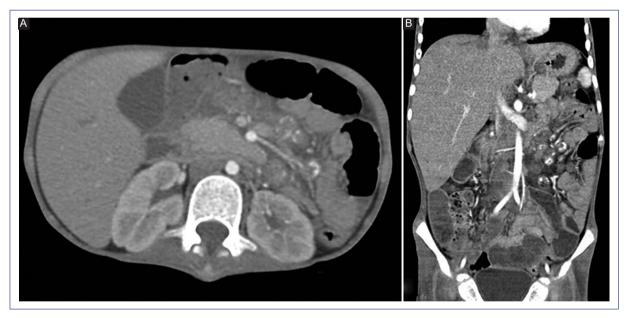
Contrast-enhanced abdominal CT scan. A: multiple ovoid mesenteric adenopathies. B: hepatomegaly, multiple retroperitoneal adenopathies with a tendency to conglomerate and some with internal calcification images.
